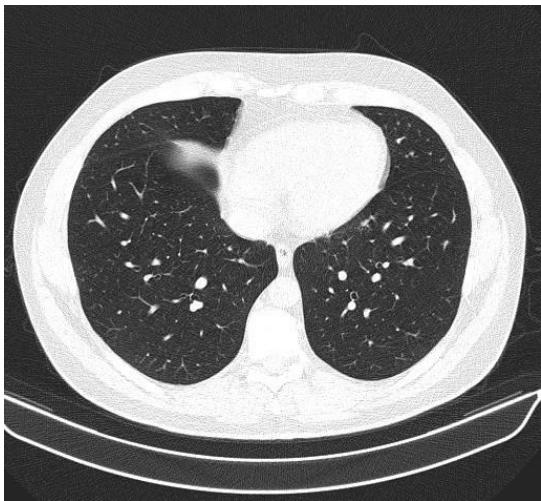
35-year-old male patient with clinical symptoms and positive RT-PCR test. HRCT does not show any changes in lung parenchyma.
